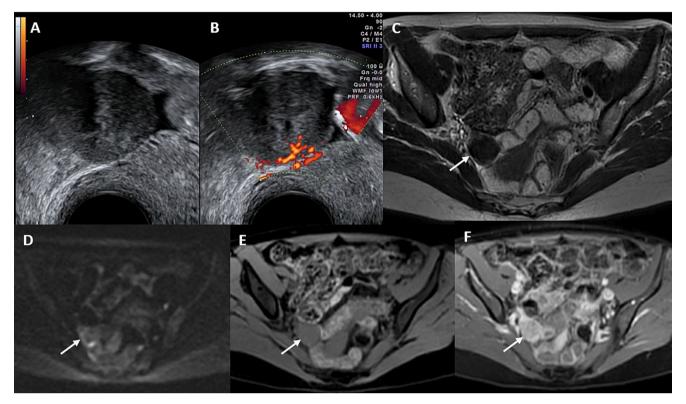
A 78-year-old female patient with a multilocular cyst measuring 62 mm on transvaginal pelvic ultrasound (A), with smooth inner walls, and a solid component corresponding to an irregular inner wall measuring 5 mm in height and 10 mm in long axis, with no Doppler flow visualized (B), and smooth septations (C), classified as O-RADS US 4. Pelvic MRI revealed that the mass contained solid tissue (indicated by the arrow) corresponding to a papillary projection in lowT2W signal (D) and low DW signal (E). This solid tissue enhanced on the Dixon T1 sequence after the injection of gadolinium (F). The MRI classification was O-RADS MRI 2, suggesting the diagnosis of cystadenofibroma, which was confirmed by pathological analysis.
